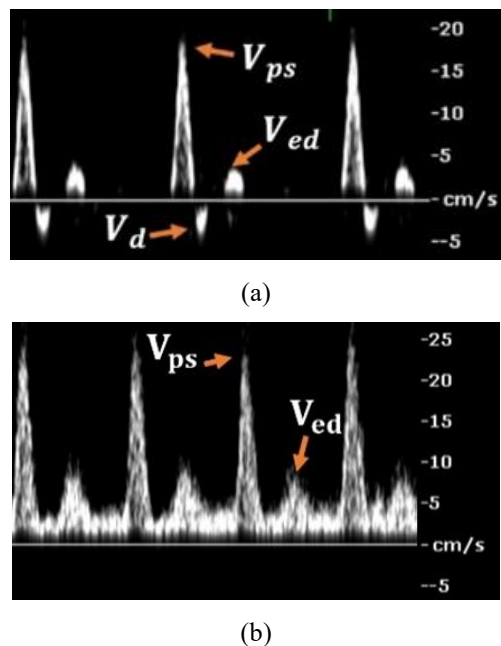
Ultrasound spectral Doppler waveforms of a 25-year-old study participant showing peak velocities at different time points in the cardiac cycle. (a) in a room with an air temperature of $20 \pm 1^\circ\text{C}$, (b) in a room with an air temperature of $30 \pm 1^\circ\text{C}$.
